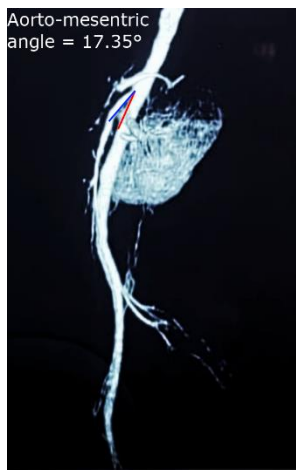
Contrast enhanced computed tomography with CT angiogram showing reduced aorto-mesenteric angle*
